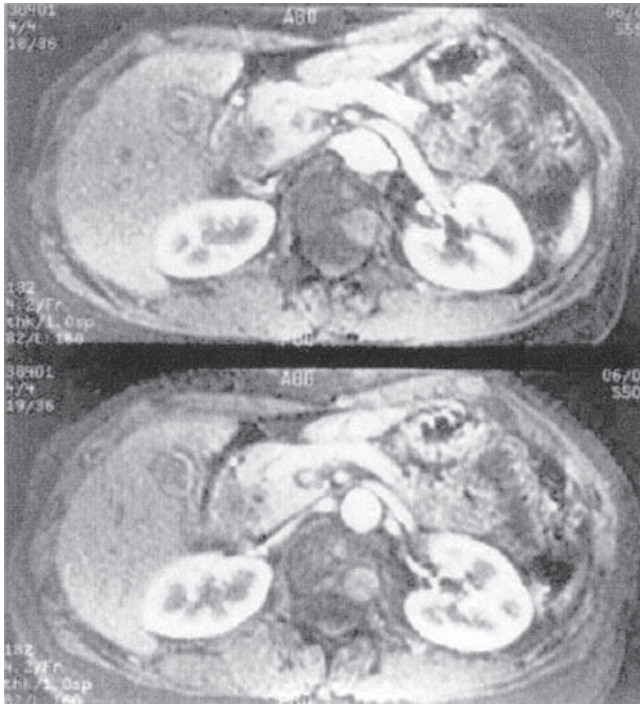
T1-weighted MR images with gadolinium contrast. A mass in the head of the pancreas appears hypodense. (Reproduced with permission from Yeo CJ, et al. Pancreatic cancer. *Curr Probl Surg.* 1999;Feb;36(2):59–152.)
